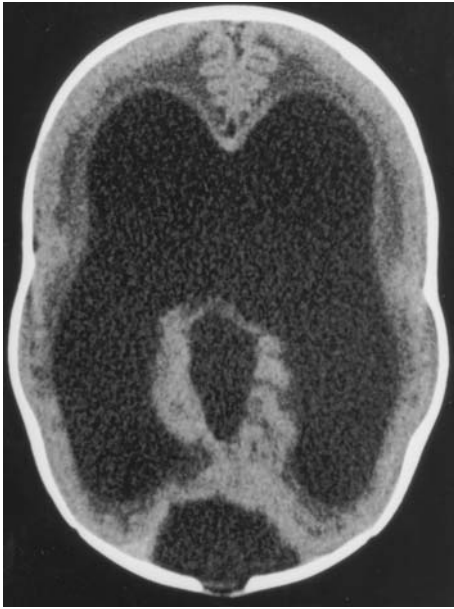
Computed tomography (CT) of newborn with microphthalmos and cataracts: broad communication between lateral ventricles, Dandy-Walker like aspect of posterior fossa (not shown), cortical migration anomalies with polymicrogyria, evident in anterior interhemispheric fissure. Diagnosis: Walker-Warburg syndrome
